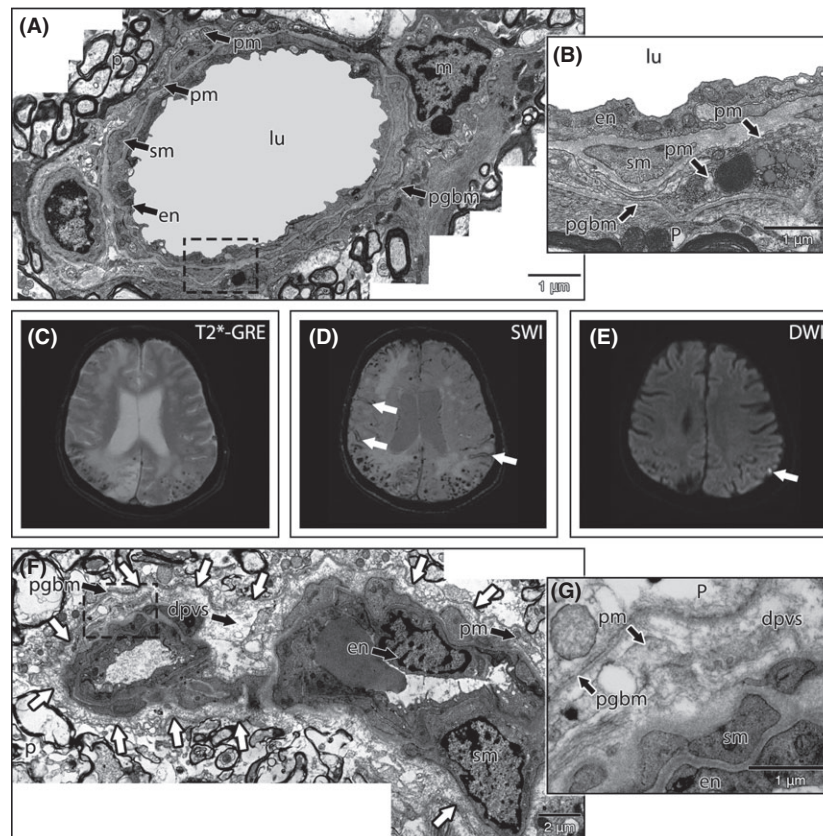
(A) Reconstructed montage of an artery from the posterior frontal subcortical white matter of a control patient. The endothelium (en), smooth muscle cells (sm) and pia mater (pm) appear normal. The pial-glial basement membrane (pgbm) is only expanded in the presence of macrophages (m). (B) High power of the vessel wall highlighted by the box seen in (A). Note the two layers of pia mater (pm) with no dilated perivascular space. (C–E) MRI of a 68-year-old with rapidly progressing dementia. The ventricles are dilated (C). Susceptibility-weighted imaging revealed multiple strictly lobar cerebral microbleeds (arrows) and widespread cortical superficial siderosis (D). Diffusion-weighted imaging showed a small cortical hyperintense lesion in the left occipital region (E). (F) Reconstructed montage of an artery from the right frontal subcortical white matter of a CAA patient. The endothelium (en) appears enlarged. There is a dilated perivascular space (dpvs) (white arrows) and expansion of the pial glial basement membrane (pgbm). The pia mater (pm) appears disrupted with only fragments visible. (G) High power of the vessel wall highlighted by the box seen in (F). Note only one layer of pia mater (PM) surrounded by a dilated perivascular space (dpvs) is visible. Other abbreviations; smooth muscle (sm); parenchyma (p); lumen (lu).
